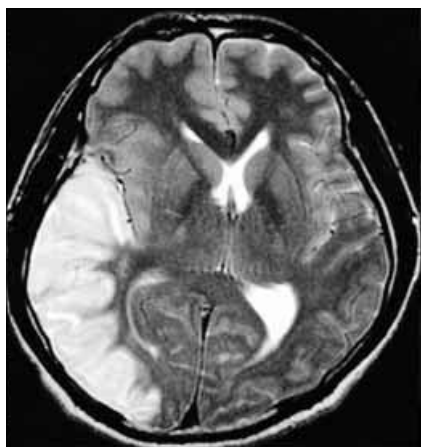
T2-weighted magnetic resonance image reveals a diffuse infarction involving the lower division of the middle cerebral artery territory.
